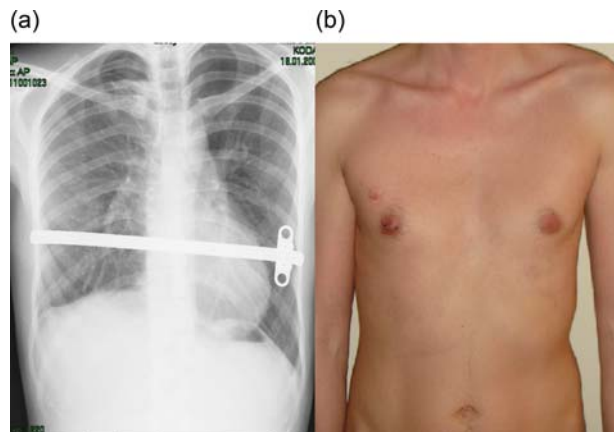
(a) Postoperative chest X-ray showing an expanded right lung with the pectus bar and (b) postoperative view of the chest wall.
